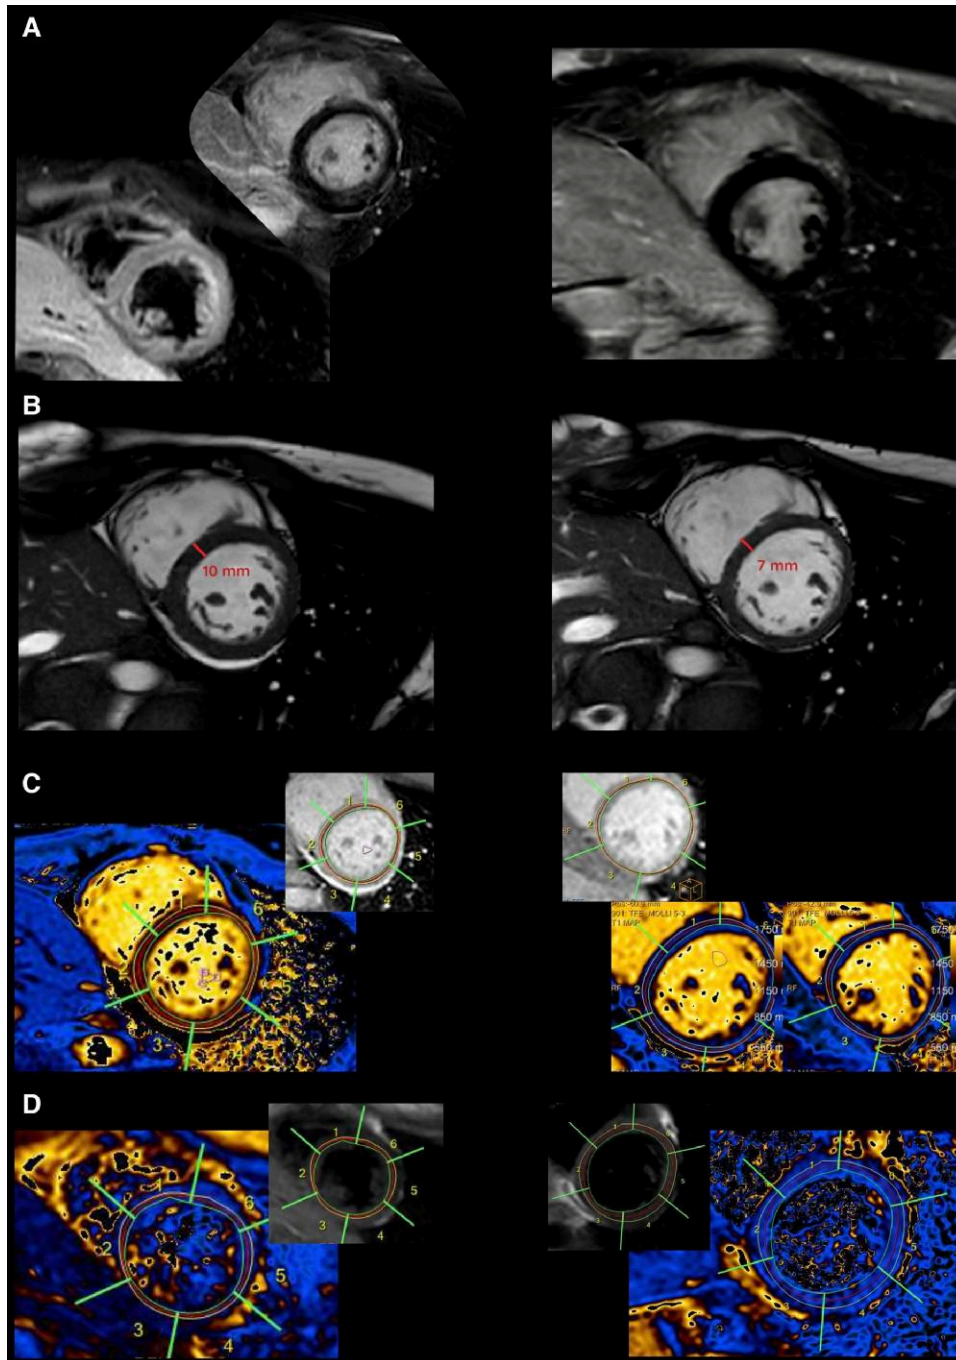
Patient 1 cardiac magnetic resonance. (A) During acute phase (on the left), T₂-weighted imaging showed a significant and diffuse increase of myocardial signal intensity, compared with skeletal muscle, reflecting oedema; nuanced late gadolinium enhancement is detectable in epi-mesocardial infero-lateral region of acute phase imaging but not in follow-up MRI (on the right). (B–D) Balanced steady-state free precession imaging (Cine imaging), T₁ and T₂ mapping during acute phase (on the left) and after 6 months (on the right): mild pericardial effusion was noted during acute phase, and no pericardial effusion at follow-up; it was associated with myocardial thickening: interventricular septum 10 mm vs. 7 mm (diastolic phase; on the left: heart rate (HR) 90 b.p.m., trigger delay 624 ms; on the right: HR 70 b.p.m., trigger delay 603 ms) (B) and significant acute increase of T₁ (C) and T₂ (D) relaxation time, respectively: T₁ mapping summary values 1185 ± 22.1 vs. 1037 ± 21; T₂ mapping summary values 60.4 ± 2.6 vs. 51 ± 3.
